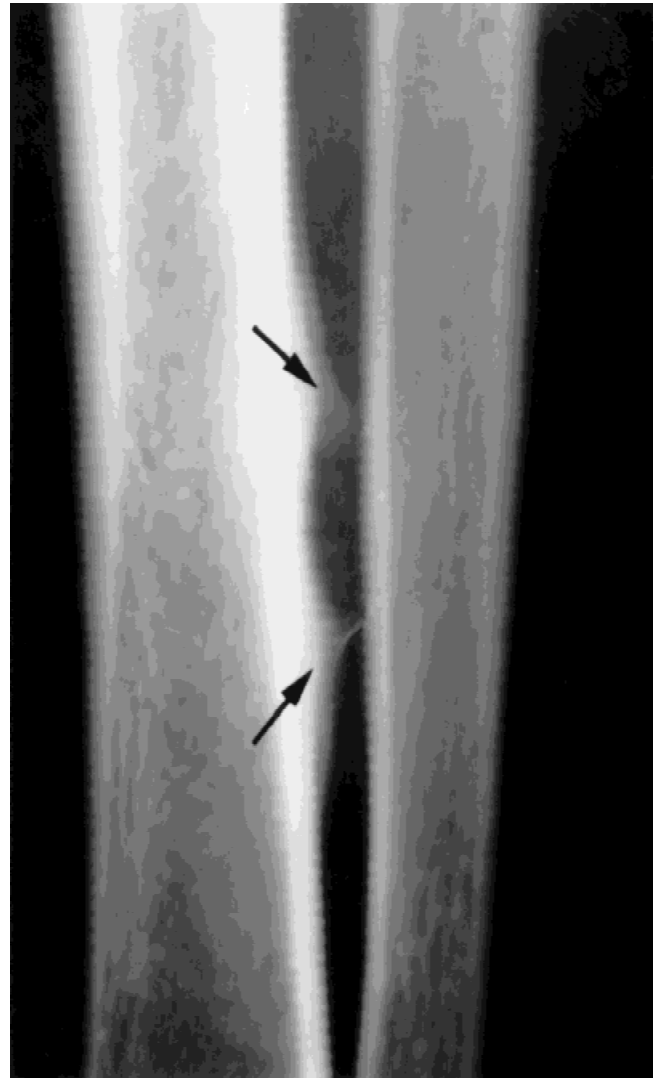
Fifty-four-year-old man with an initial presentation of progressive pain below his knee. Plain films of the tibia revealed saucerized intracortical destruction with a ring of reactive bone (arrows). Adenocarcinoma of the lung was diagnosed subsequently.
